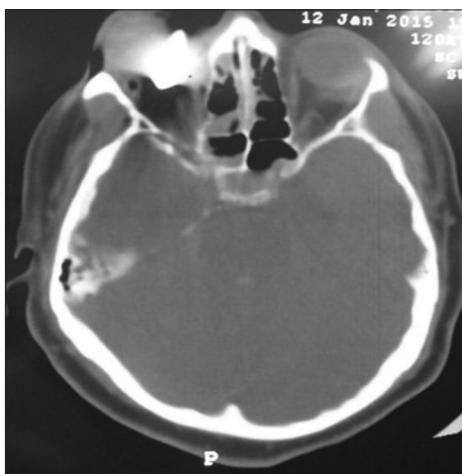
A head computed tomography scan (Axial section) bone window shows a bullet lodged in the right intra-orbital region with possible tract hematoma extending from the right occipital bone.
